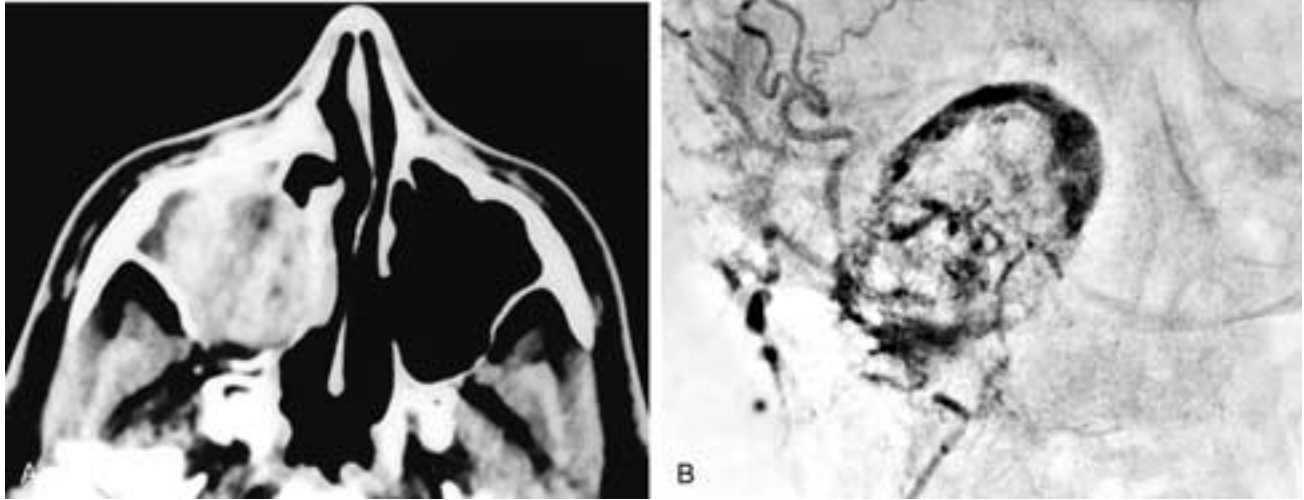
Axial contrast-enhanced CT scan (A) and coronal subtraction angiogram (B) show an expansile enhancing and vascular mass in the right maxillary sinus. This patient had metastatic hypernephroma.
